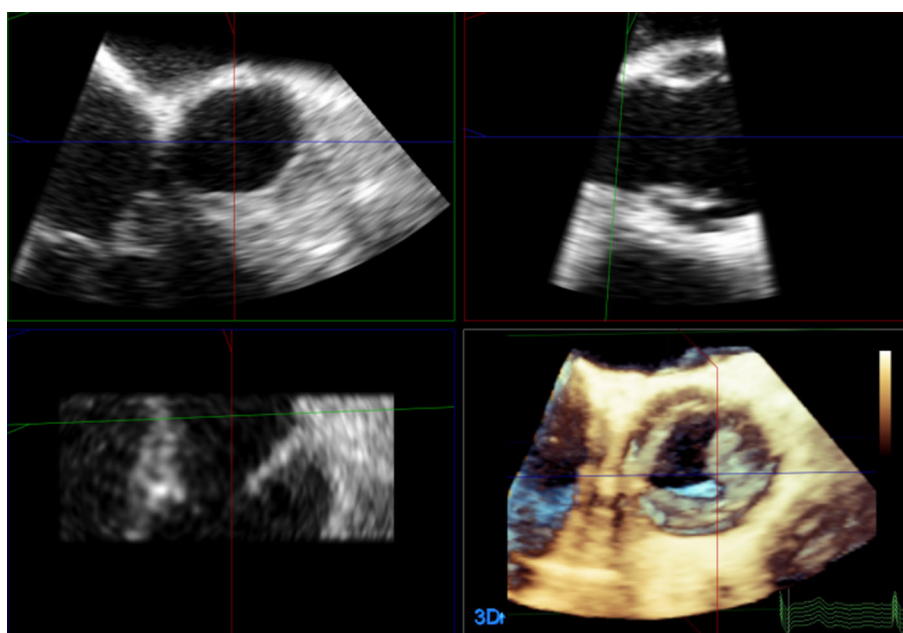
Transesophageal 3D echo: multi-planar reconstruction of the left ventricular outflow tract, showing its asymmetric shape
